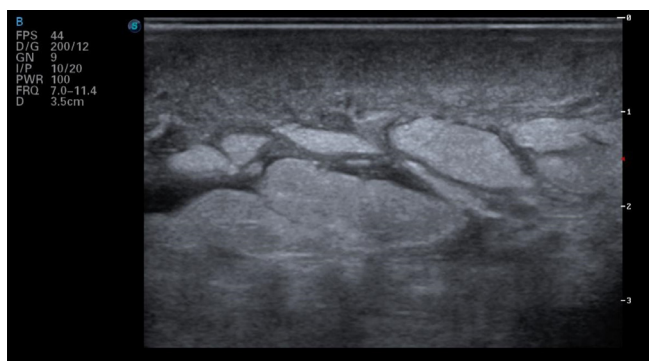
Ultrasound image showing persistence of hypoechoic lines of free fluid in subcutaneous cellular tissue of the lower external quadrant of the right breast
